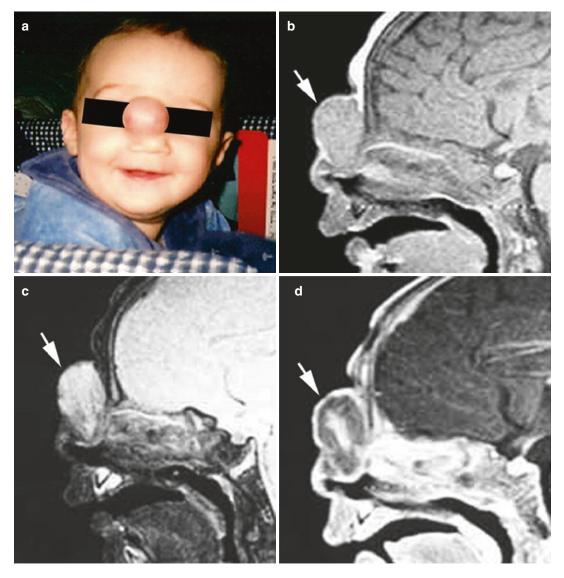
(a) Extranasal glioma in a infant boy with a bulbous frontonasal mass. a Clinical photo shows a reddish frontonasal mass that enlarged with crying [3]. MRI imaging of Extranasal glioma in a infant boy with a bulbous frontonasal mass. (b) Sagittal T1-W image demonstrates a large frontonasal mass that is slightly hyperintense
